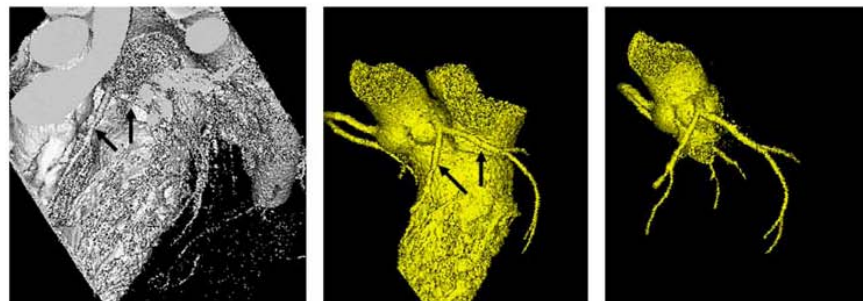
Steps to segment the LCA for the generation of 3D coronary models. Three-dimensional CT volume data show the visualisation of the LCA (arrows in left image). After applying image processing, the ascending aorta, coronary arteries and cardiac chambers are segmented from the volume data (middle image). Further image segmentation allows for the ascending aorta and coronary arteries to be kept while the remaining structures are removed (right image).
